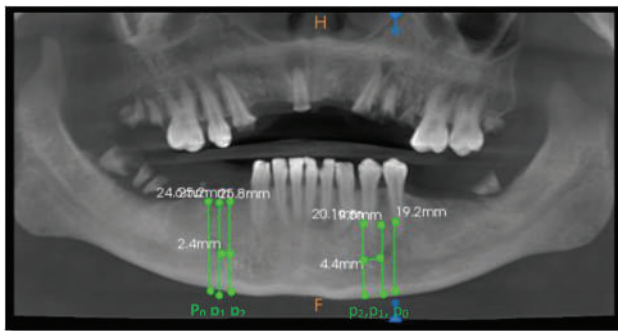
CBCT images with anterior loop length in panoramic view. CBCT, cone-beam computed tomography
